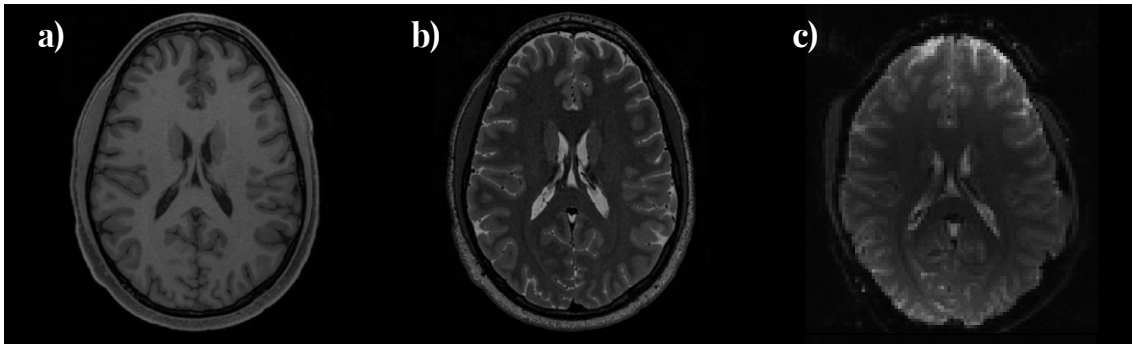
Visualization of different MRI modalities: In a) there is a T1-weighted image, in b) a T2-weighted image, and in c) a T2* image.
